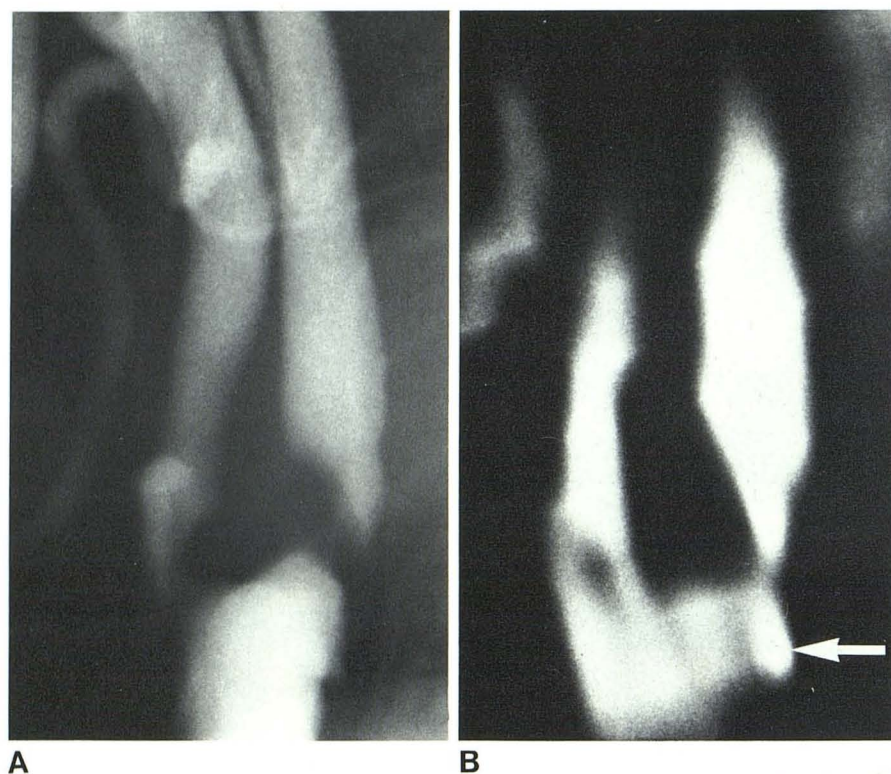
Carotid angiogram (A) and incremental dynamic CT scan (B). Marked stenosis (grade 5) of internal and external carotid arteries. Calcified plaque at origin of internal carotid artery (arrow).
